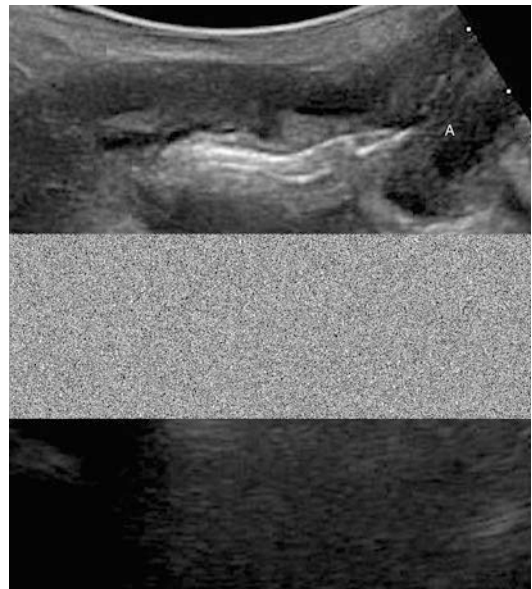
Transperineal ultrasound. Exam performed with convex 2D probe with natural contrast (air and feces). Sagittal scan during straining. Rectorectal intussusception: the rectal walls fold on themselves, entering into the lumen of the rectum; the apex of the intussusceptum facing the anal canal can be observed
